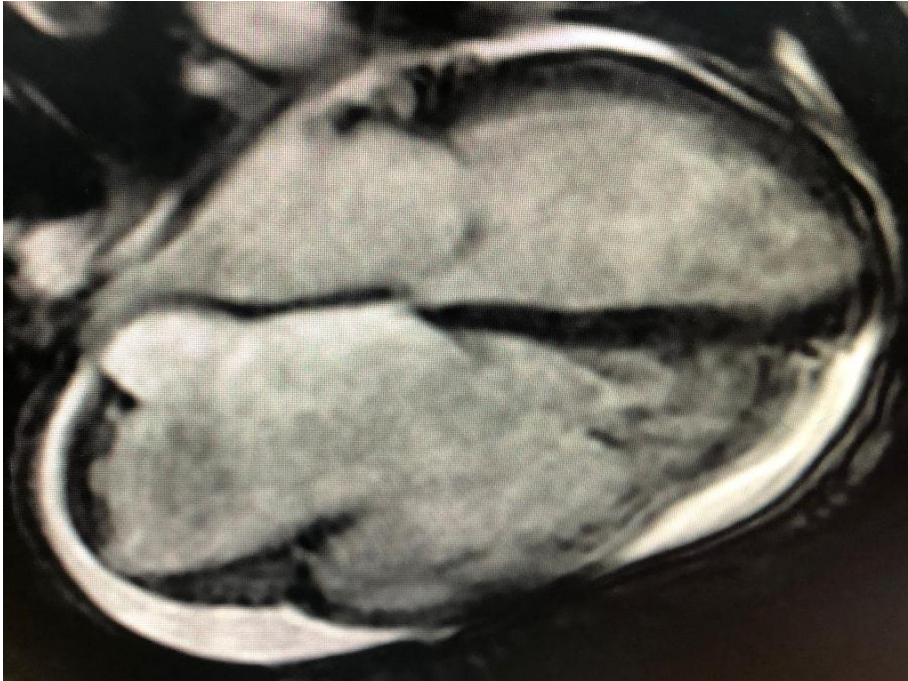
Cardiac MRI: cross section showing a dilated right ventricle with an impaired ejection fraction of 21%.
